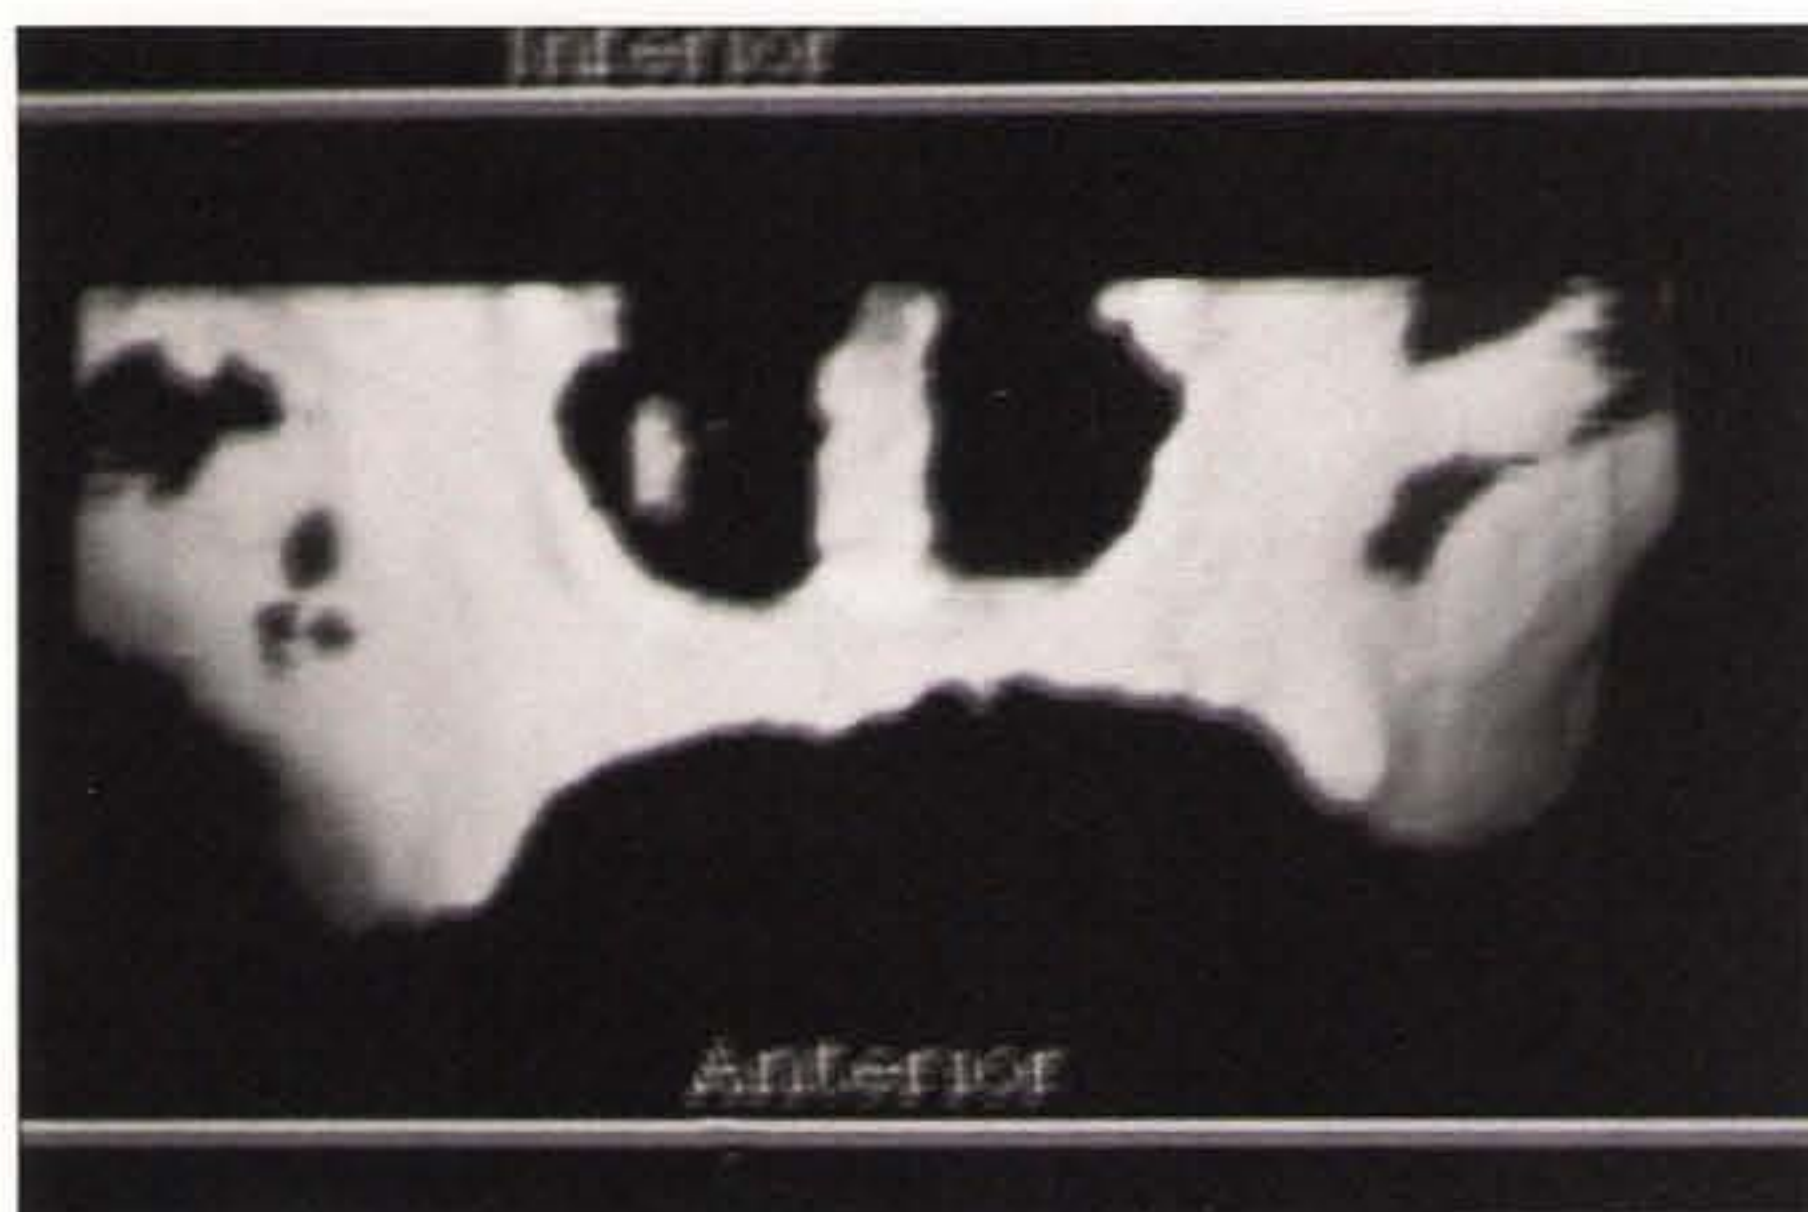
Three-dimensional CT revealing serious bone resorption in the maxillary incisive bone.
